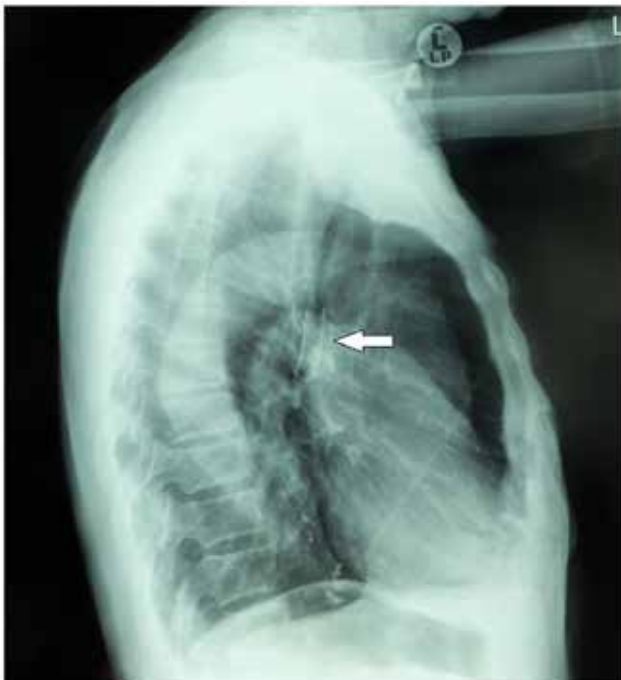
Chest x-ray lateral view showing the fragment of the tracheostomy tube and signs of chronic obstructive lung disease.
